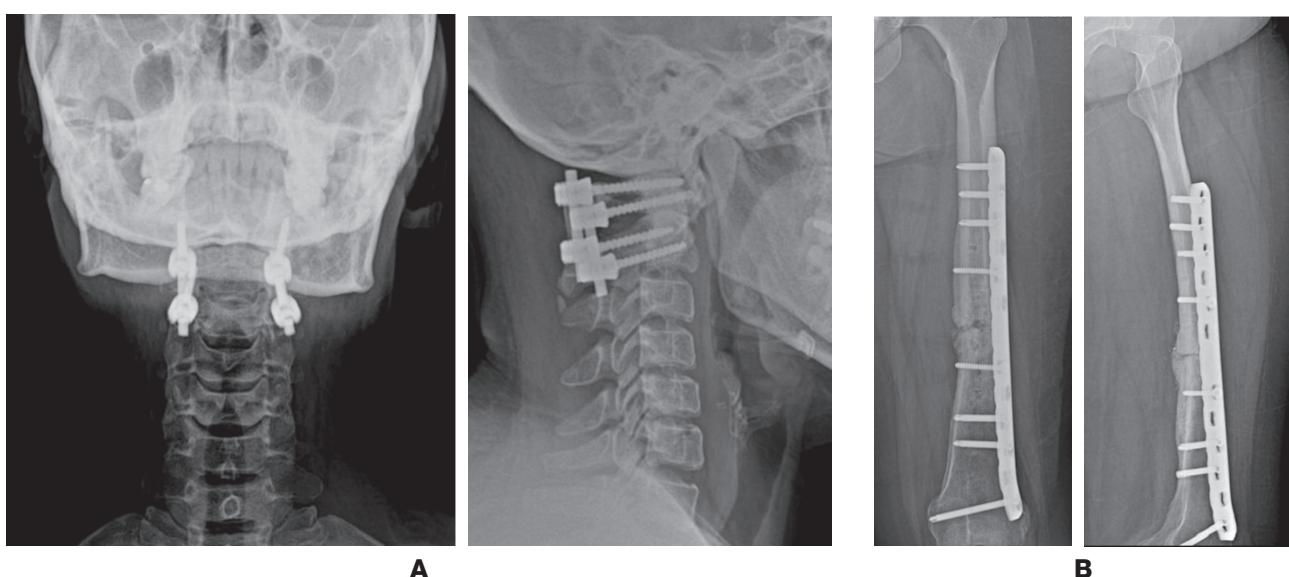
Plain radiographs of cervical spine at 6 months (A), and left femur (B) at 1 year of the follow-up.
